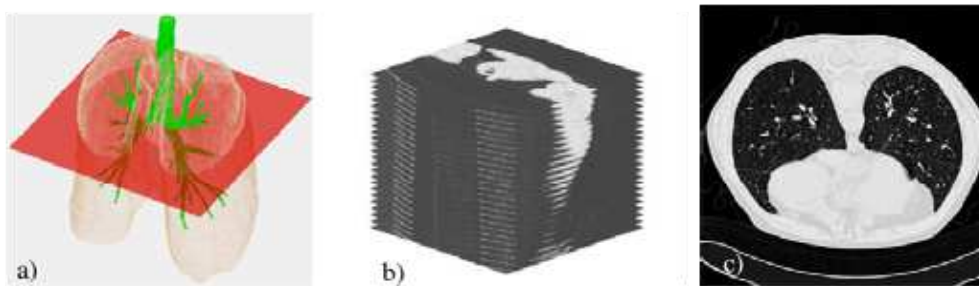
Examples of a human lung (a), a series of HRCT images (b) and an axial image with normal anatomy (c).
